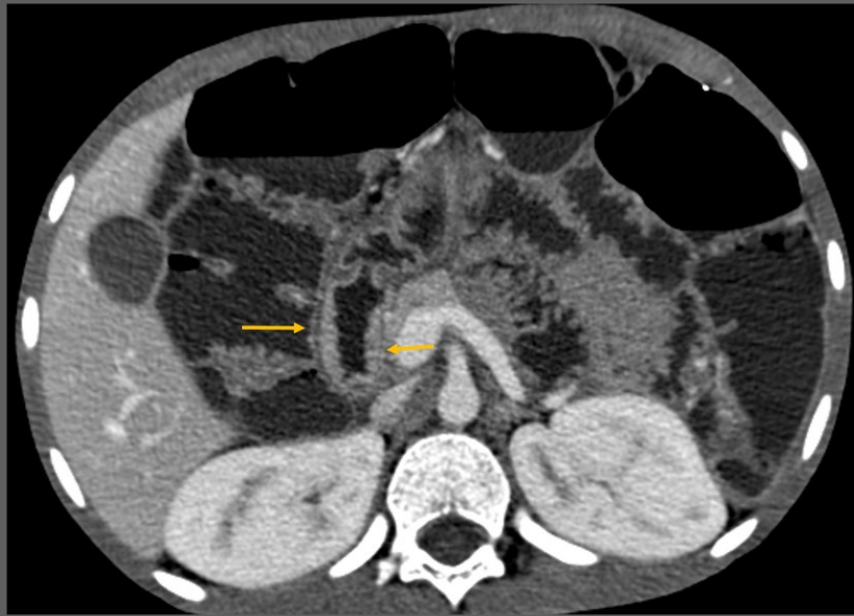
Axial CT enterographic sections of a 14-year-old boy, shows thickening and irregularity of the duodenal mucosa (arrows), with intense enhancement. Duodenal biopsy revealed disappearance of the "villi" associated with crypt hyperplasia, consistent with celiac disease.
